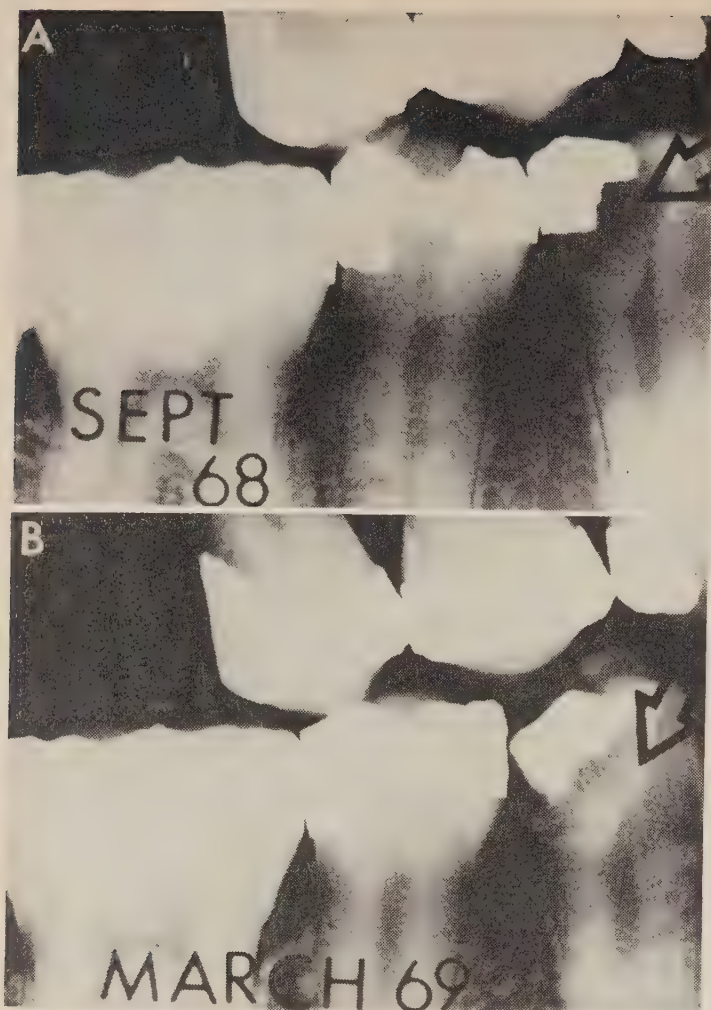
A, bitewing radiograph of right posterior teeth of a 28 year old patient. Arrow indicates an active carious lesion beneath a silver amalgam restoration. B, the same tooth six months after indirect pulp capping. Arrow indicates radiopaque area of apparent remineralization.
